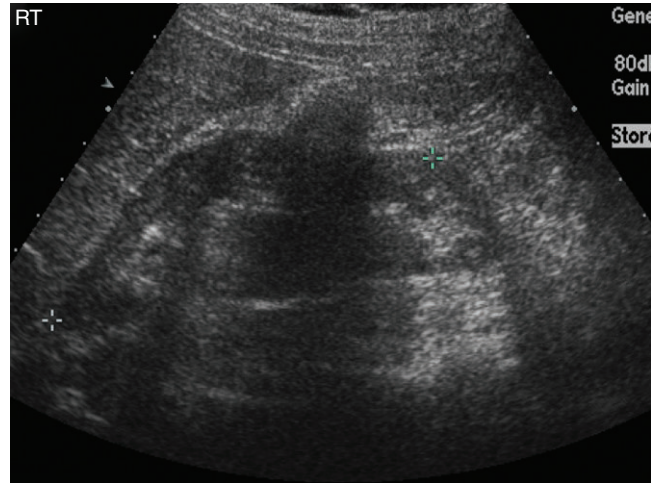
Another ultrasound image to the right demonstrates the mass connecting to the lower pole of the right kidney. Similar connection was seen on the left side (not shown), confirming the diagnosis of horseshoe kidney.
